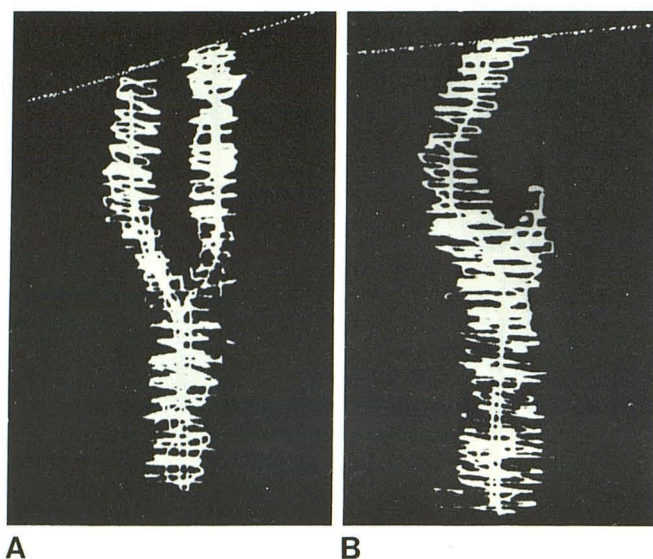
Doppler carotid bifurcation images. A, Normal. B, Complete occlusion of internal carotid.
